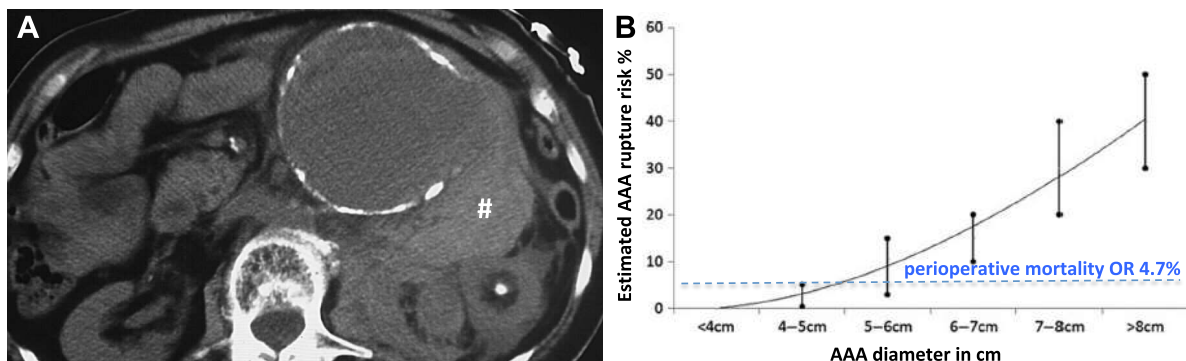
Ruptured AAA. CT-angiography showing an AAA with retroperitoneal rupture (A). Note the interrupted aortic aneurysm wall and the large retroperitoneal hematoma (#) (author's own material). The annual risk of rupture increases with AAA diameter (B). Currently the cut-off for surgical repair is based on comparison with the perioperative mortality from open repair (OR) (blue line) (graph modified from Chaikof et al.¹⁹).
